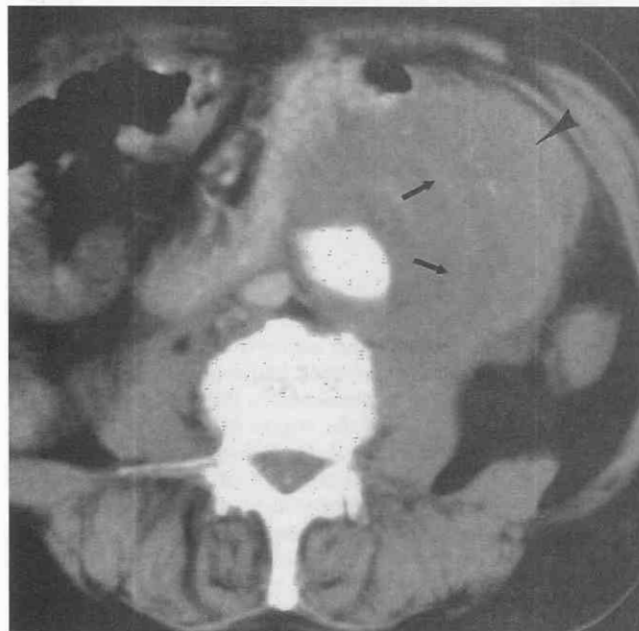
Large abdominal aortic aneurysm with crescent sign. Contrast-enhanced CT scan shows a crescent of high attenuation (arrows) in the aneurysm thrombus. This finding is believed to indicate that the aneurysm is likely to rupture in the near future. Indeed, rupture has already occurred, as evidenced by the poorly defined hematoma (arrowhead) located peripheral to calcification in the aortic wall.
